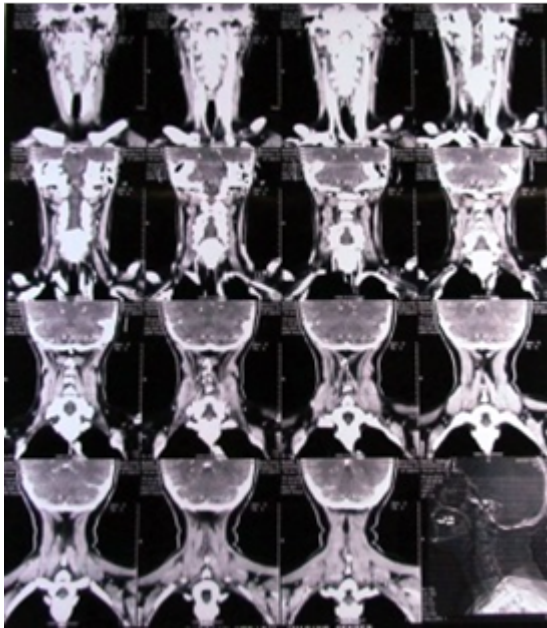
Chest x-ray; c, contrast-enhanced CT scan of the neck
